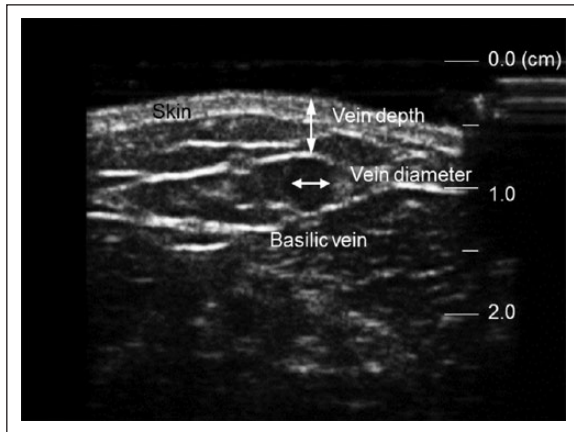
Transverse view of a basilic vein with ultrasound for the measurement of the vein depth and vein diameter.
